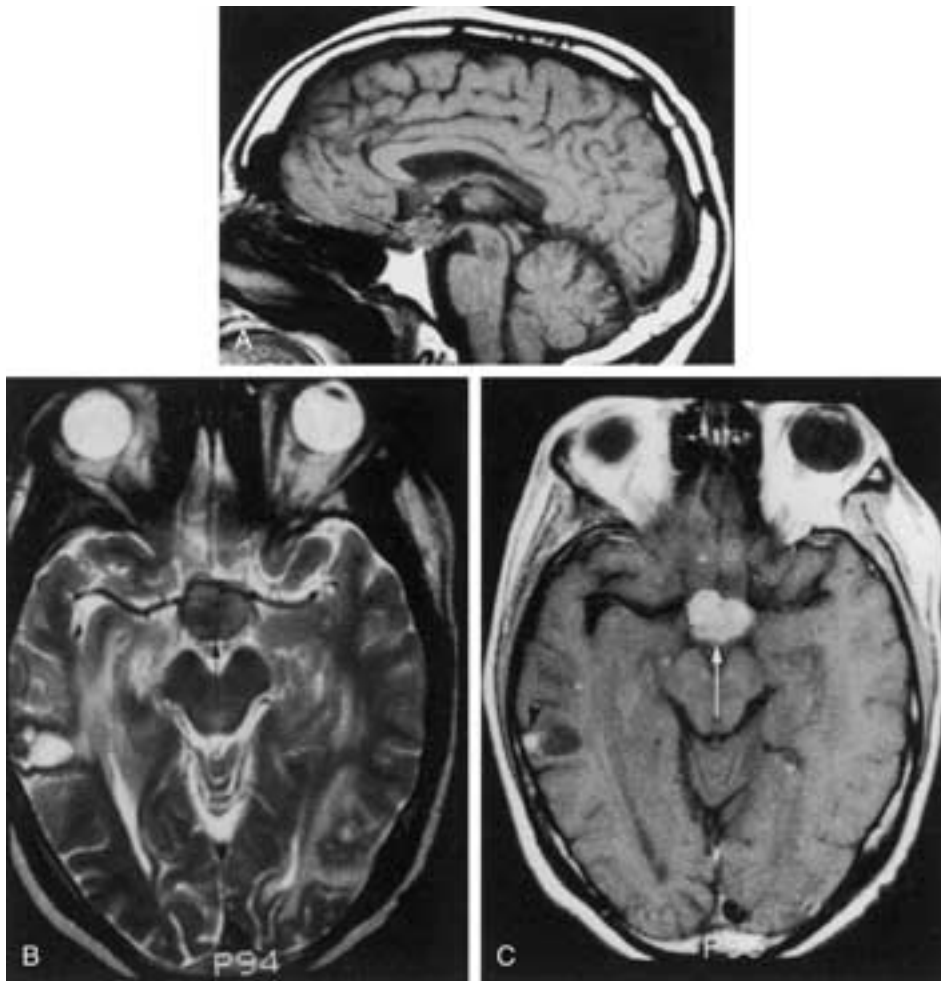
Metastatic carcinoma of the breast in a 60-year-old female with known carcinoma of the breast presenting with visual loss. A, Sagittal T1-weighted MR image shows an irregular mass (*arrow*) involving the optic chiasm. B, Axial T2-weighted image shows metastasis (*arrow*) to the optic chiasm to be hypointense, with a hypointense metastasis in the right temporal lobe surrounded by hyperintense vasogenic edema. There is a diffuse increase in signal intensity throughout the white matter secondary to prior radiation therapy. C, Axial T1-weighted MR image after gadolinium injection shows enhancement of both the chiasmatic mass (*arrow*) and the right temporal tumor (*arrowhead*).
